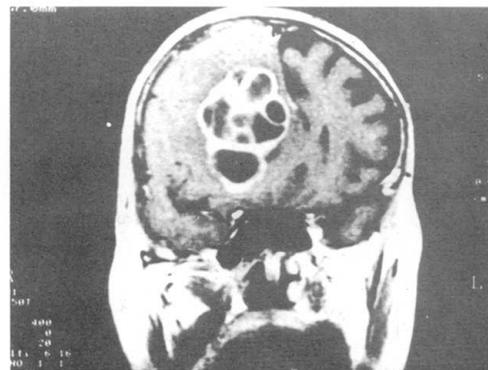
CE coronal MRI (SE 400/20) showing a right frontal lobe multicystic mass. There is prominent rim enhancement of the cyst walls. The mass is causing some distortion in the midline structures.
